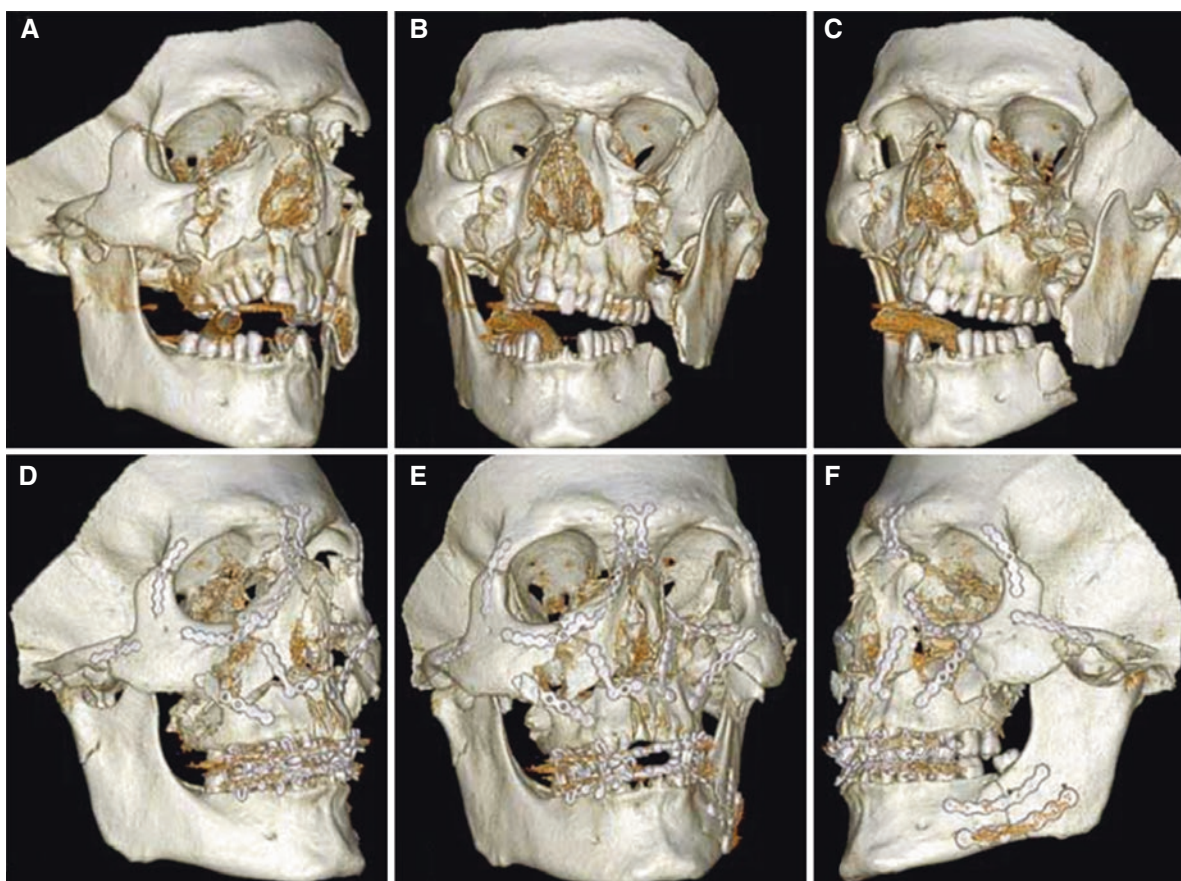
LeFort 1, 2, 3 and mandibular fractures; 28-year-old male, motor vehicle crash. (A, B, C) Preoperative and (D, E, F) postoperative 3D CT images show a mixture of all LeFort fractures and, additionally, mandibular fractures
